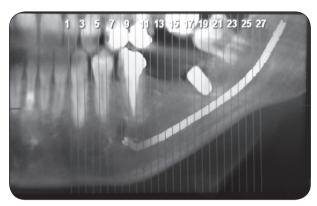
Photograph showing CBCT for implant placement after 6 months.
